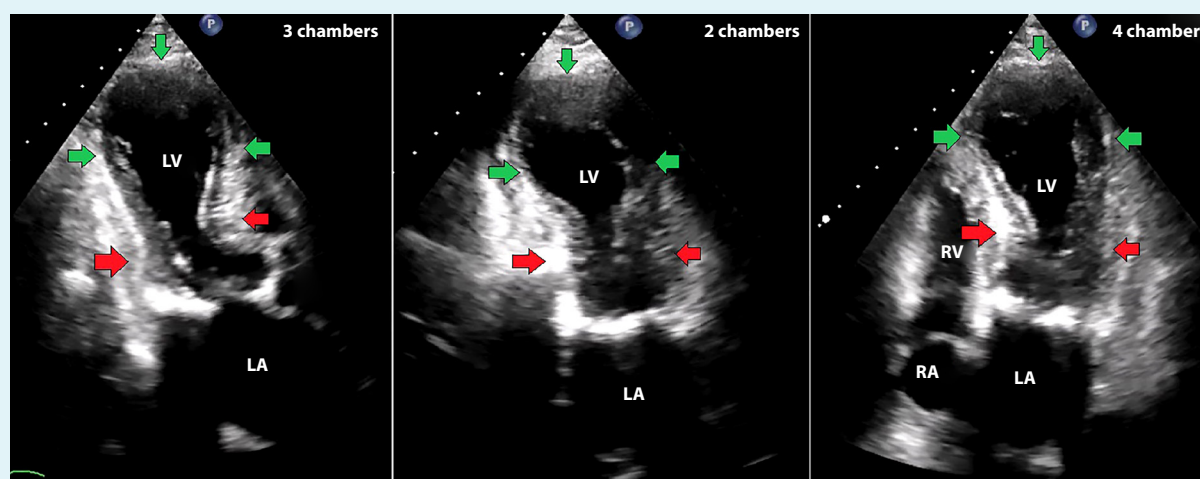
Echocardiography in apical view of 3, 2, and 4 chambers. Evidence of akinesia of the anterior, inferior, anteroinferolateral and anteroinferoseptal walls at medial and apical levels (green arrow) and basal hypercontractility (red arrow) (Takotsubo pattern). RA: right atrium. LA: left atrium. Ao: aorta. RV: right ventricle. LV: left ventricle.
